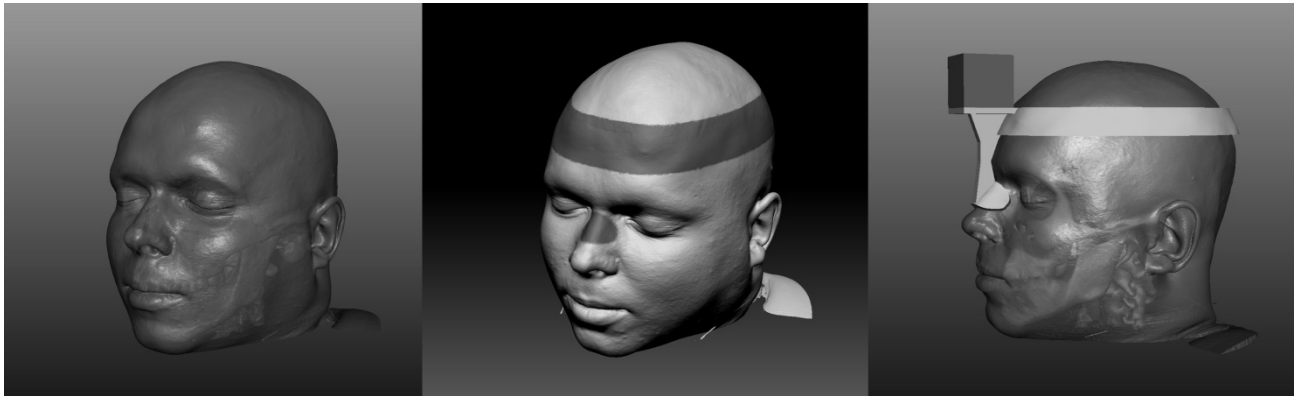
Left image – Extracted face and skull models form CT; middle – marked areas, right – shell model with cuboid maker on top.
